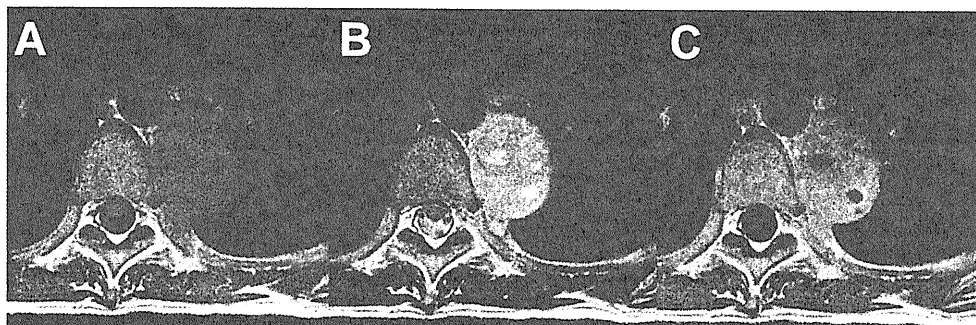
A) MRI of the chest showing that, compared with the spinal cord, the tumor was iso-intense on T1-weighted images, and B) moderately intense with foci of signal heterogeneity on T2-weighted images. C) Gadolinium enhancement was moderate and inhomogeneous on T1-weighted images.
